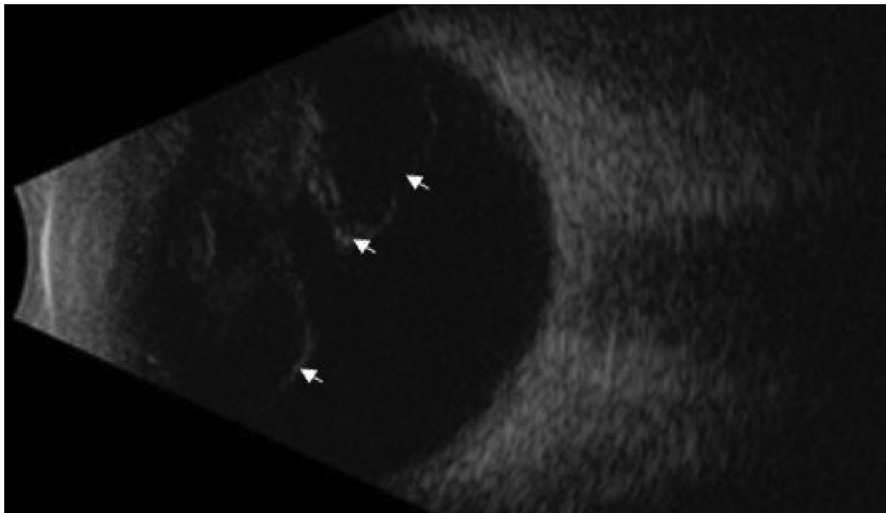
Sonographic features of PVD (arrows), presented in a 30 year old male. Signs of an irregular shaped membrane with no posterior pole attachment were also noticed.
